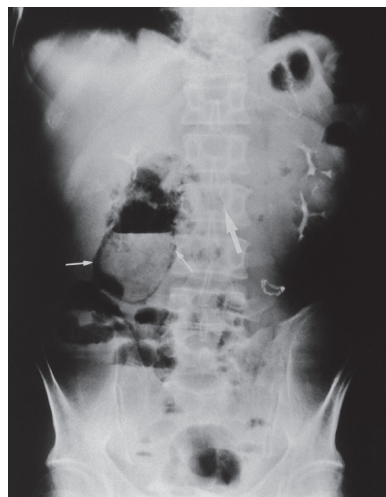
Plain abdominal X-ray film demonstrating gas forming in the gallbladder wall and lumen (small arrows). The large arrow is pointing to the stapler of duodenojejunosomy in jejunal pouch double tract reconstruction.
